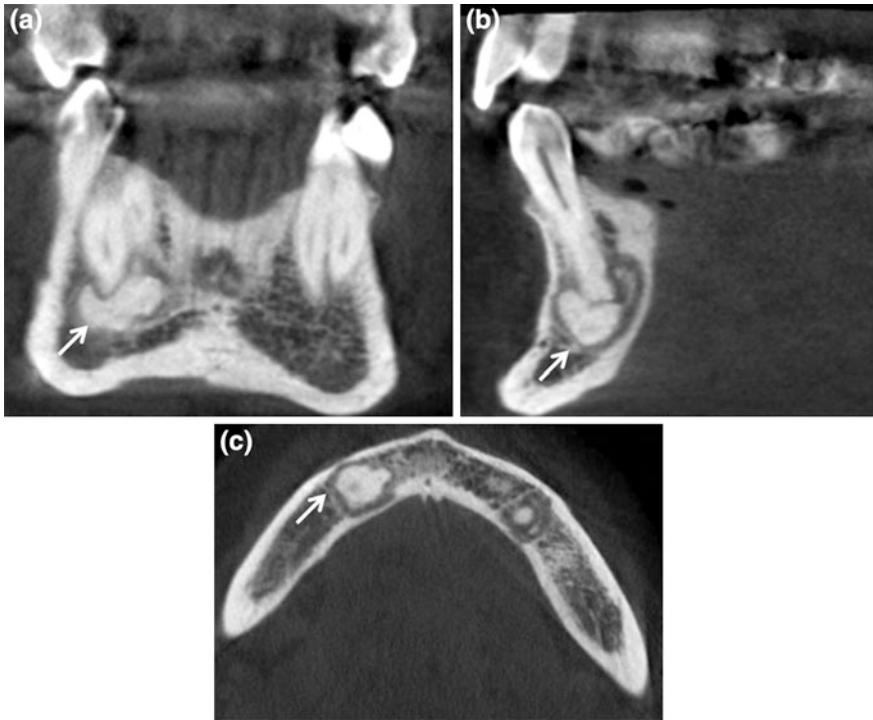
CBCT coronal (a), sagittal (b) and axial (c) sections showing a dense, lobulated radiopaque shadow extending into the mandible near the apex of 44 (*thin arrow*). This high density masse surrounded by a low density layer appears connected with the buccal–lingual and vestibular cortical plates and confirms the diagnosis of multiple cementoma
